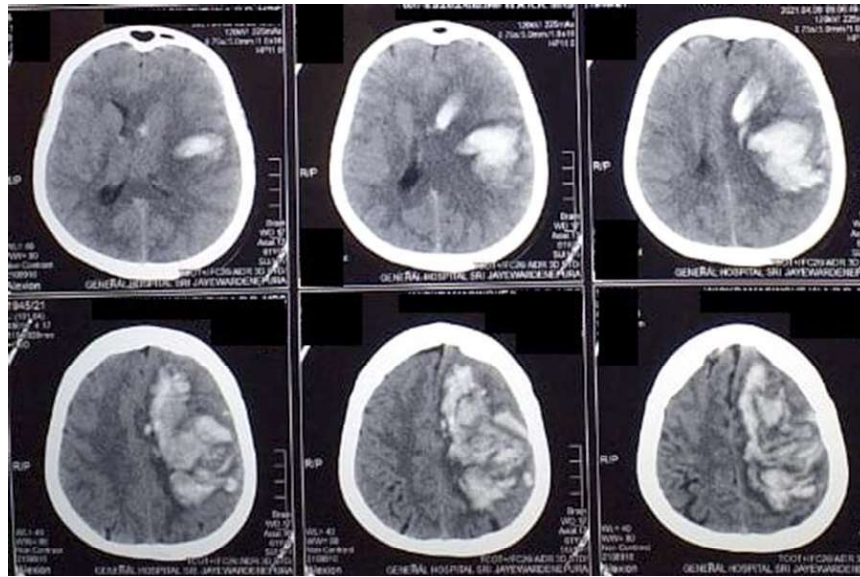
Non-contrast CT of brain at 12 hours after admission showing large intra-cerebral and intraventricular haemorrhage on the left side.
